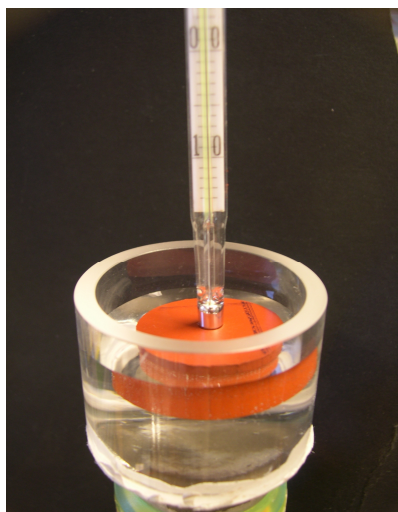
Example of a measurement set-up to measure the temperature rise due to ultrasound in absorbing material.
